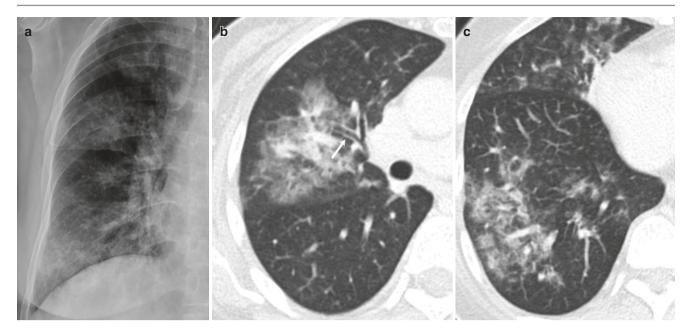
Bronchopneumonia. (a) Chest radiograph shows patchy ground-glass opacities in the right lung. (b, c) Axial CT images show peribronchial ground-glass opacities with bronchial wall thickening (arrow)
